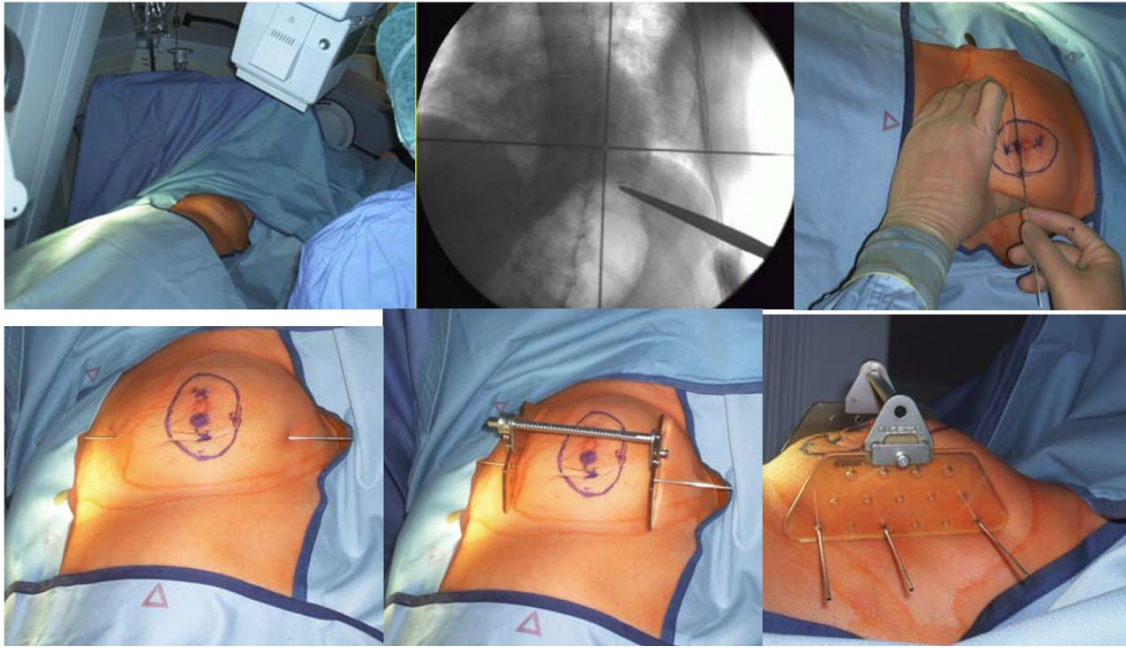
X-Ray guided implantation with closed cavity and clips markers.
